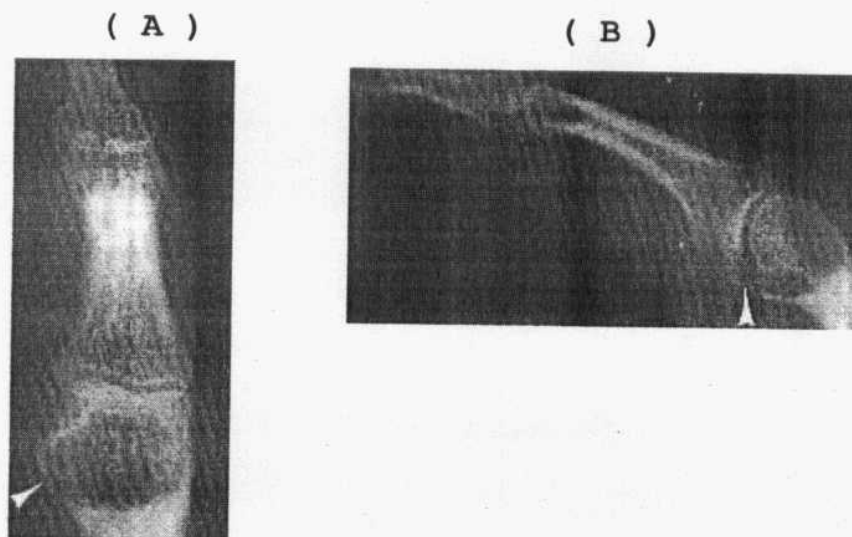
Posteroanterior (A) and lateral (B) radiographs of an enchondroma in the distal aspect of the proximal phalanx there is pathological fracture (arrow head) that resulted in its detection (Quoted from Berquist, 2003).
